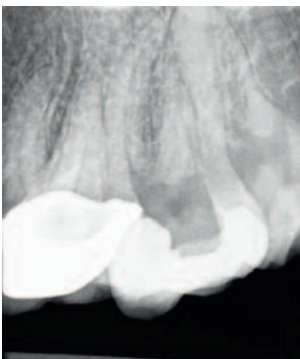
Radiographic examination six months post treatment. No signs of periapical pathology could be observed
